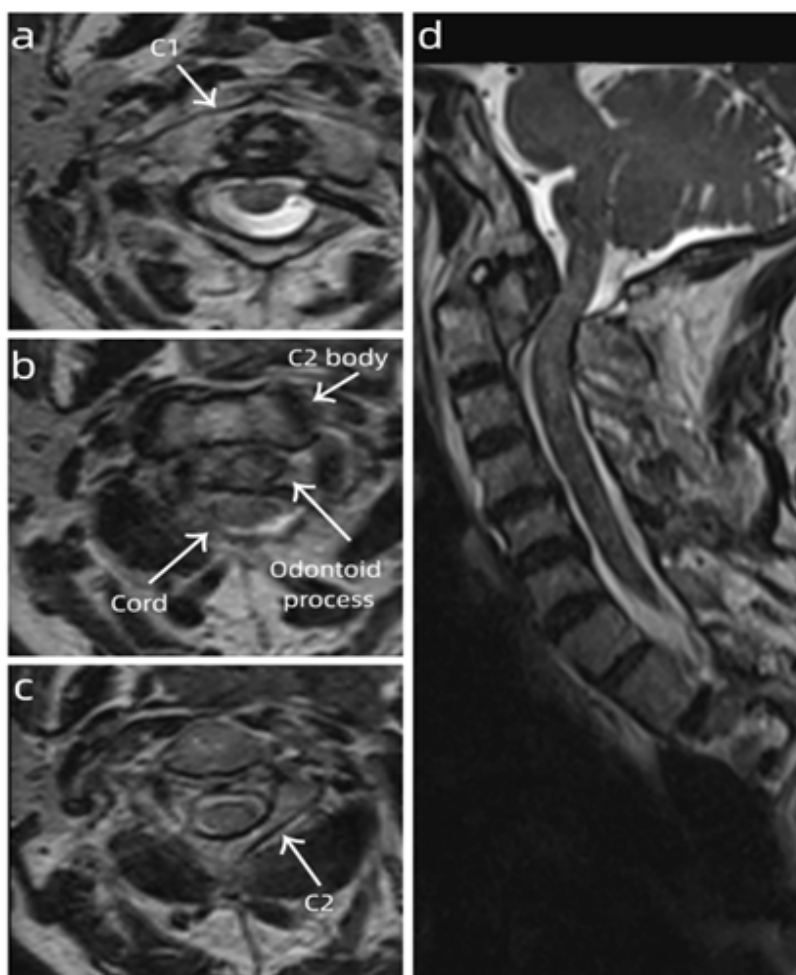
T2-weighted magnetic resonance imaging images.
